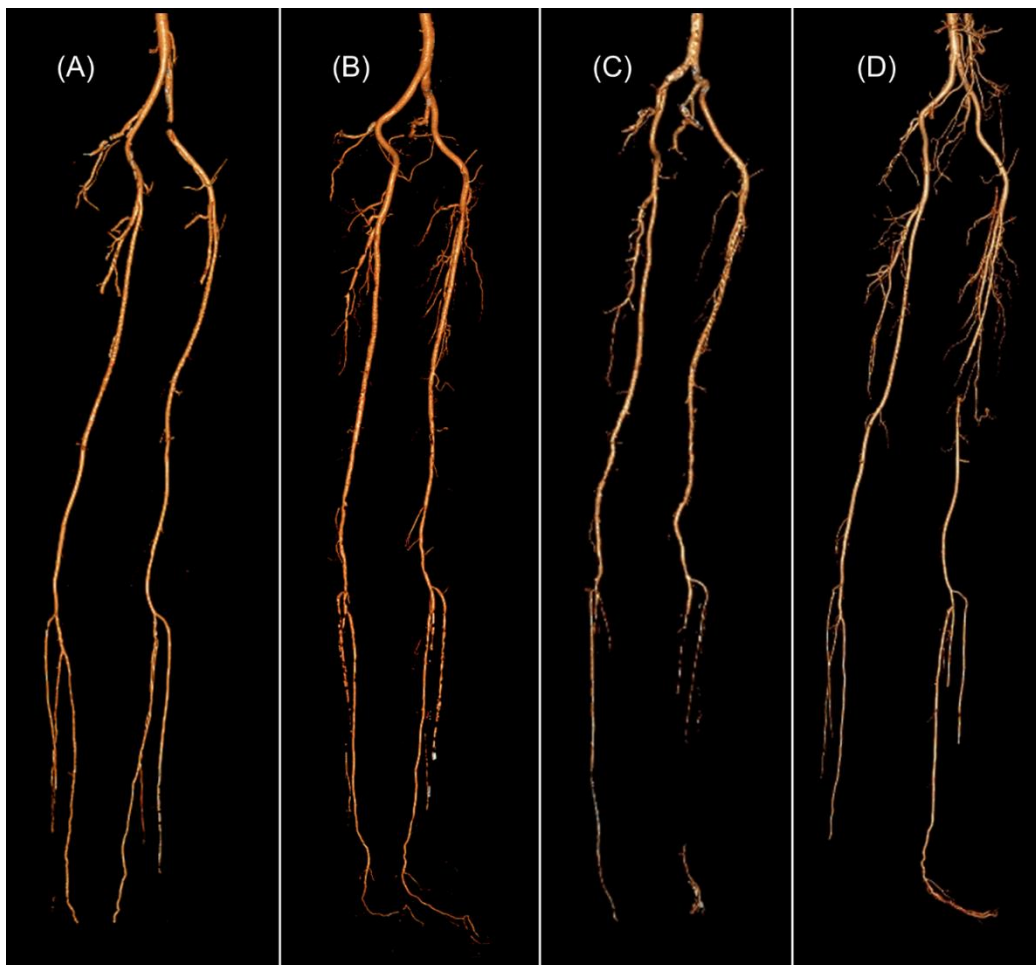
A VR image of a lower limb vessels. CT images of a (A) 55 years old male patients scanned with protocol A, (B) 72 years old male patients scanned with protocol B, (C) 70 years old female patient scanned with protocol C, and (D) 63 years old male patient scanned with protocol D.
